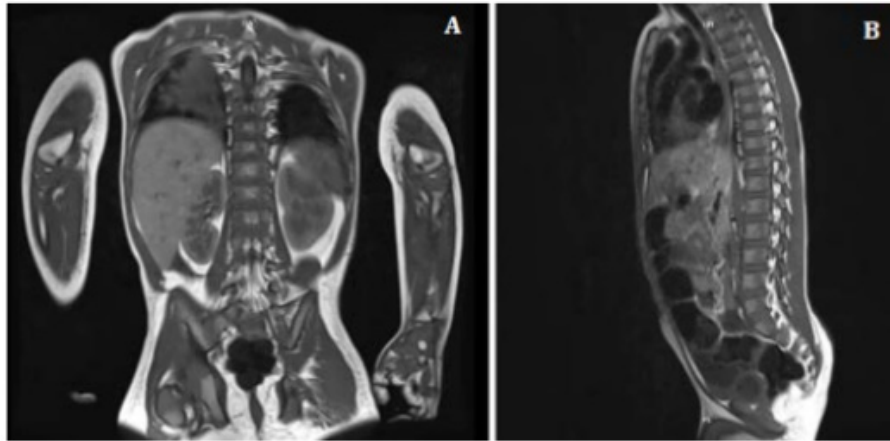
Thoracic spine MRI with gadolinium. Panel A shows the coronal view and Panel B the sagittal view. The examination demonstrates normal vertebral alignment, preserved spinal canal caliber, no abnormal enhancement, and no lesions suggestive of thoracic metastatic dissemination
